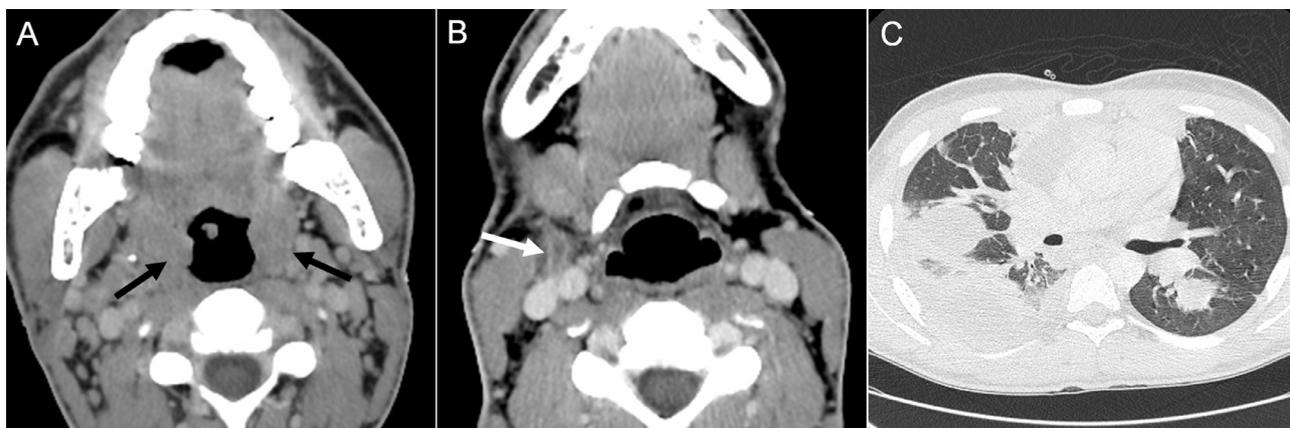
A 16-year-old with pharyngitis. Contrast-enhanced CT images of the neck in the axial planes (A,B) demonstrate evidence of enlarged bilateral tonsils (A, black arrows). The internal jugular veins are patent bilaterally; however, on the right, there is a filling defect within a confluent trunk that drains the retromandibular vein and tonsillar vein (B, white arrow). An axial CT scan of the lungs shows multifocal air space opacities consistent with multifocal pneumonia as well as a large right pleural effusion. The constellation of findings represents another case of Lemierre's syndrome. In this case though, a smaller tributary vein is thrombosed rather than the internal jugular vein.
